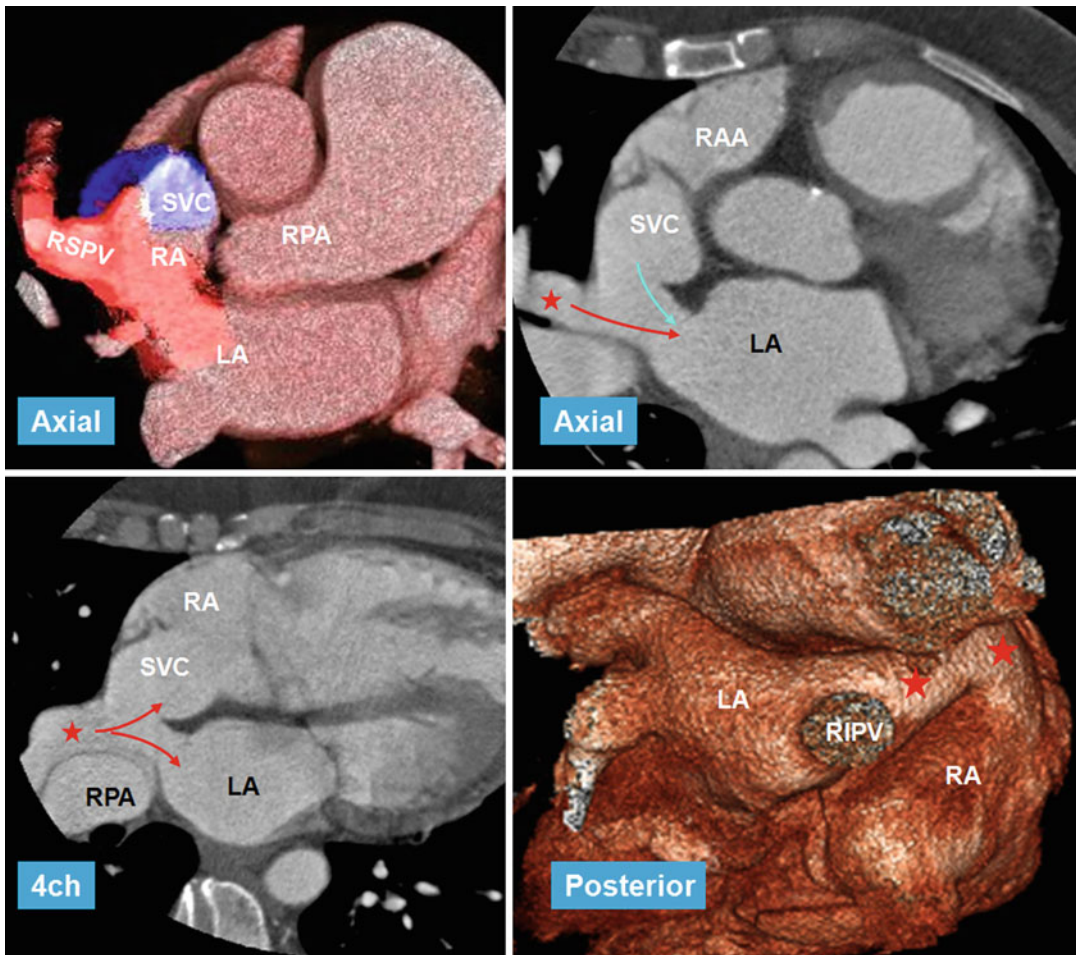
CT images in 56-year-old female referred for evaluation of right heart enlargement and pulmonary hypertension showing sinus venosus defect as a result of anomalous connection of the right superior pulmonary vein (RSPV) (red stars) to the superior vena cava (SVC) while maintaining its connection to the left atrium (LA) (venous-venous malformation). Overriding of RSPV
